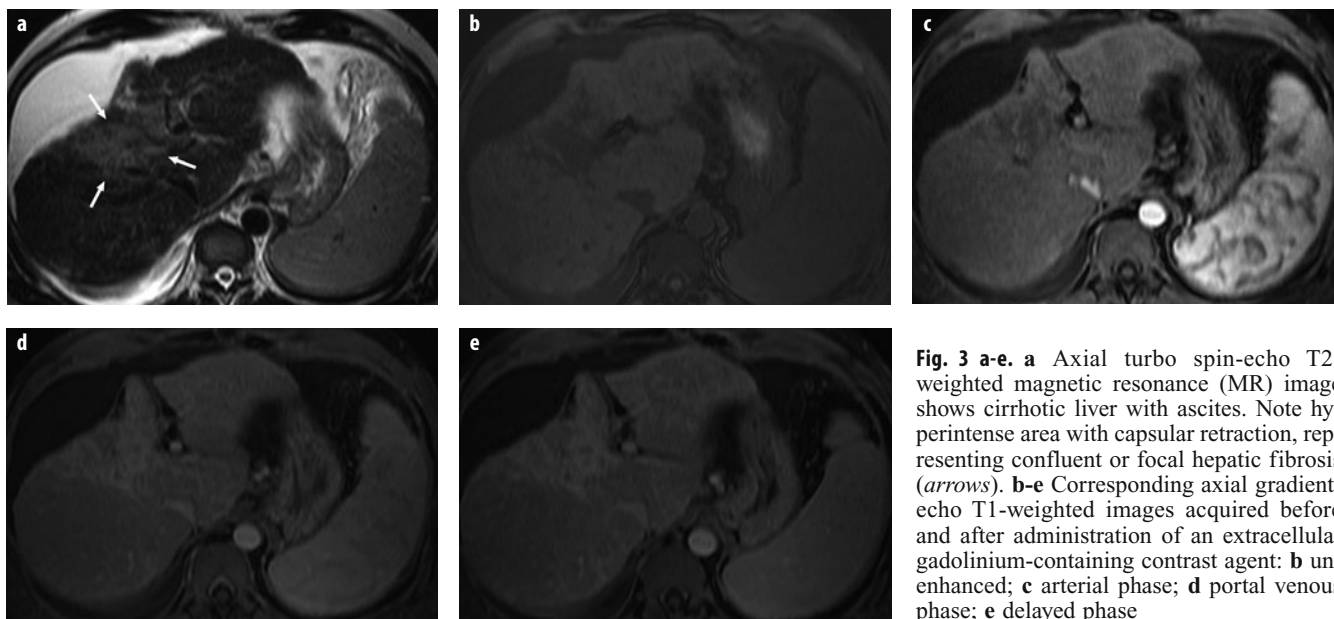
a-e. a Axial turbo spin-echo T2-weighted magnetic resonance (MR) image shows cirrhotic liver with ascites. Note hyperintense area with capsular retraction, representing confluent or focal hepatic fibrosis (arrows). b-e Corresponding axial gradient-echo T1-weighted images acquired before and after administration of an extracellular gadolinium-containing contrast agent: b unenhanced; c arterial phase; d portal venous phase; e delayed phase
